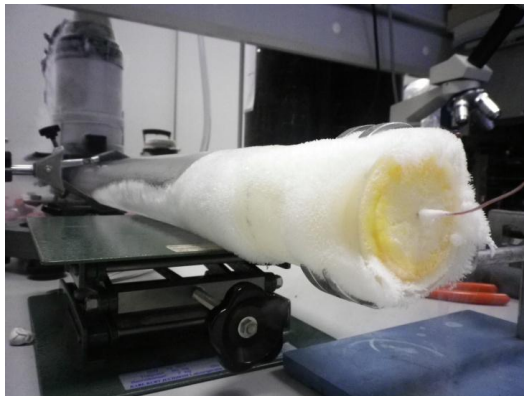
Formation of frost around the CT bed during one of the cooling experiments
